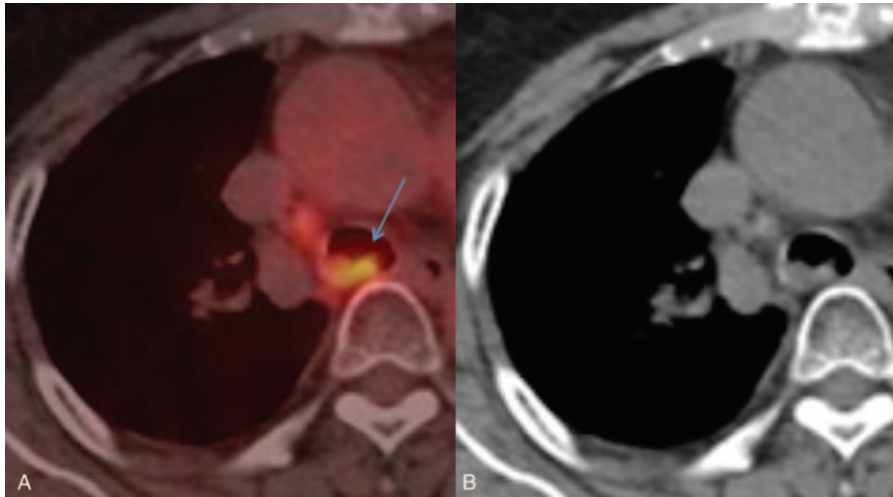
Case 1 (A and B): intratracheal metastasis from colon cancer in a 73-year-old woman. ^{18}F -FDG PET/CT image showing high ^{18}F -FDG uptake (SUVmax: 5.8) within the intratracheal fungating mass (arrow) with an irregular margin (A). Noncontrast CT scan of a combined PET/CT obtained at the level of the distal trachea shows a fungating mass about 15 mm in size in the distal trachea (B).
